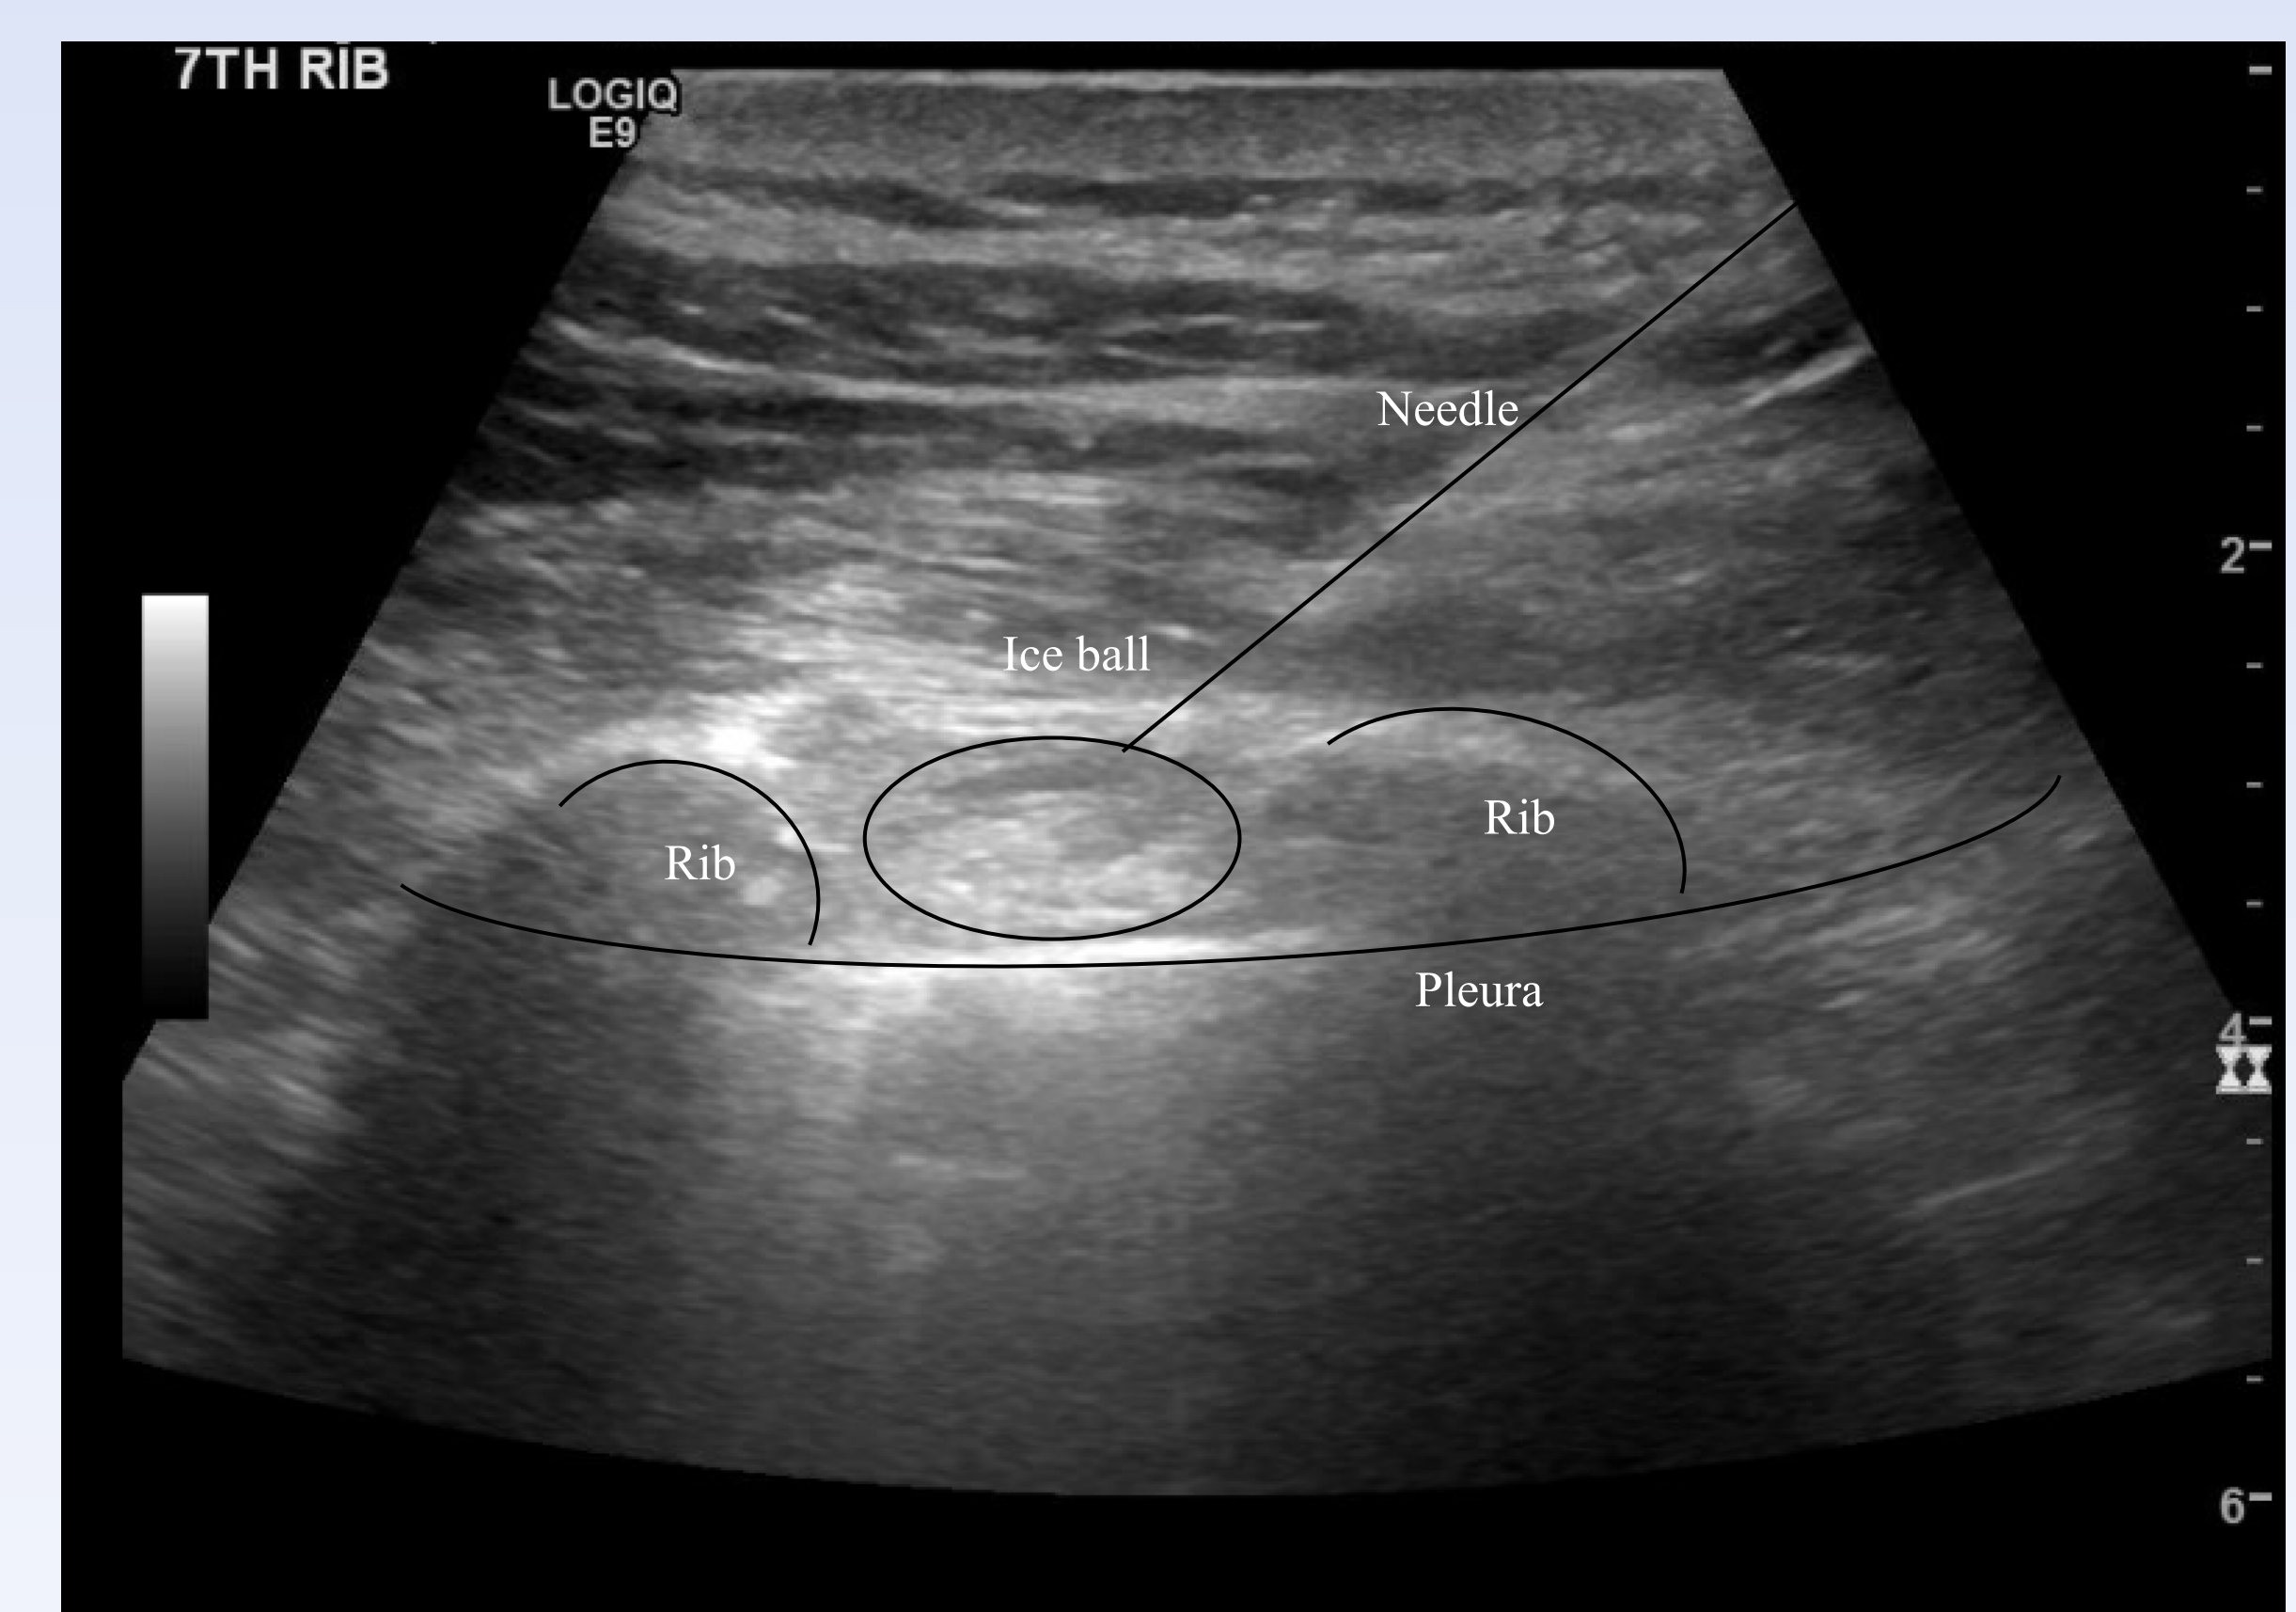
Ultrasound of ice ball in between ribs during TINC
